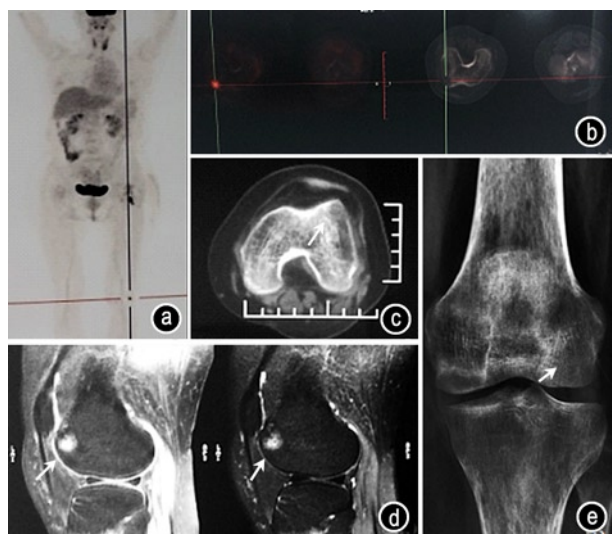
(a and b) PET/CT showing foci of abnormal radiotracer uptake in the distal femur. (c–e) X-ray, CT, and MRI showing high signal intensity in the condyle of the femur and a small tumor (arrows)
